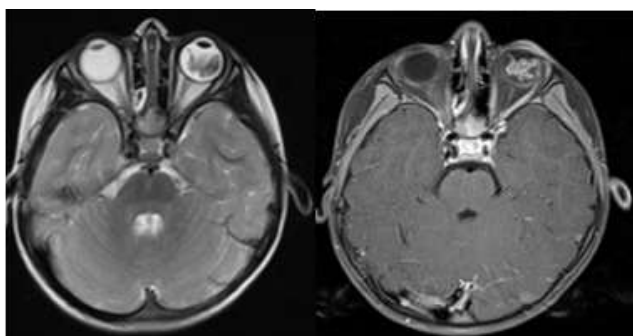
MRI orbit showing T2 hypointense lesion with heterogeneous enhancement noted in the left eye globe consistent with retinoblastoma
